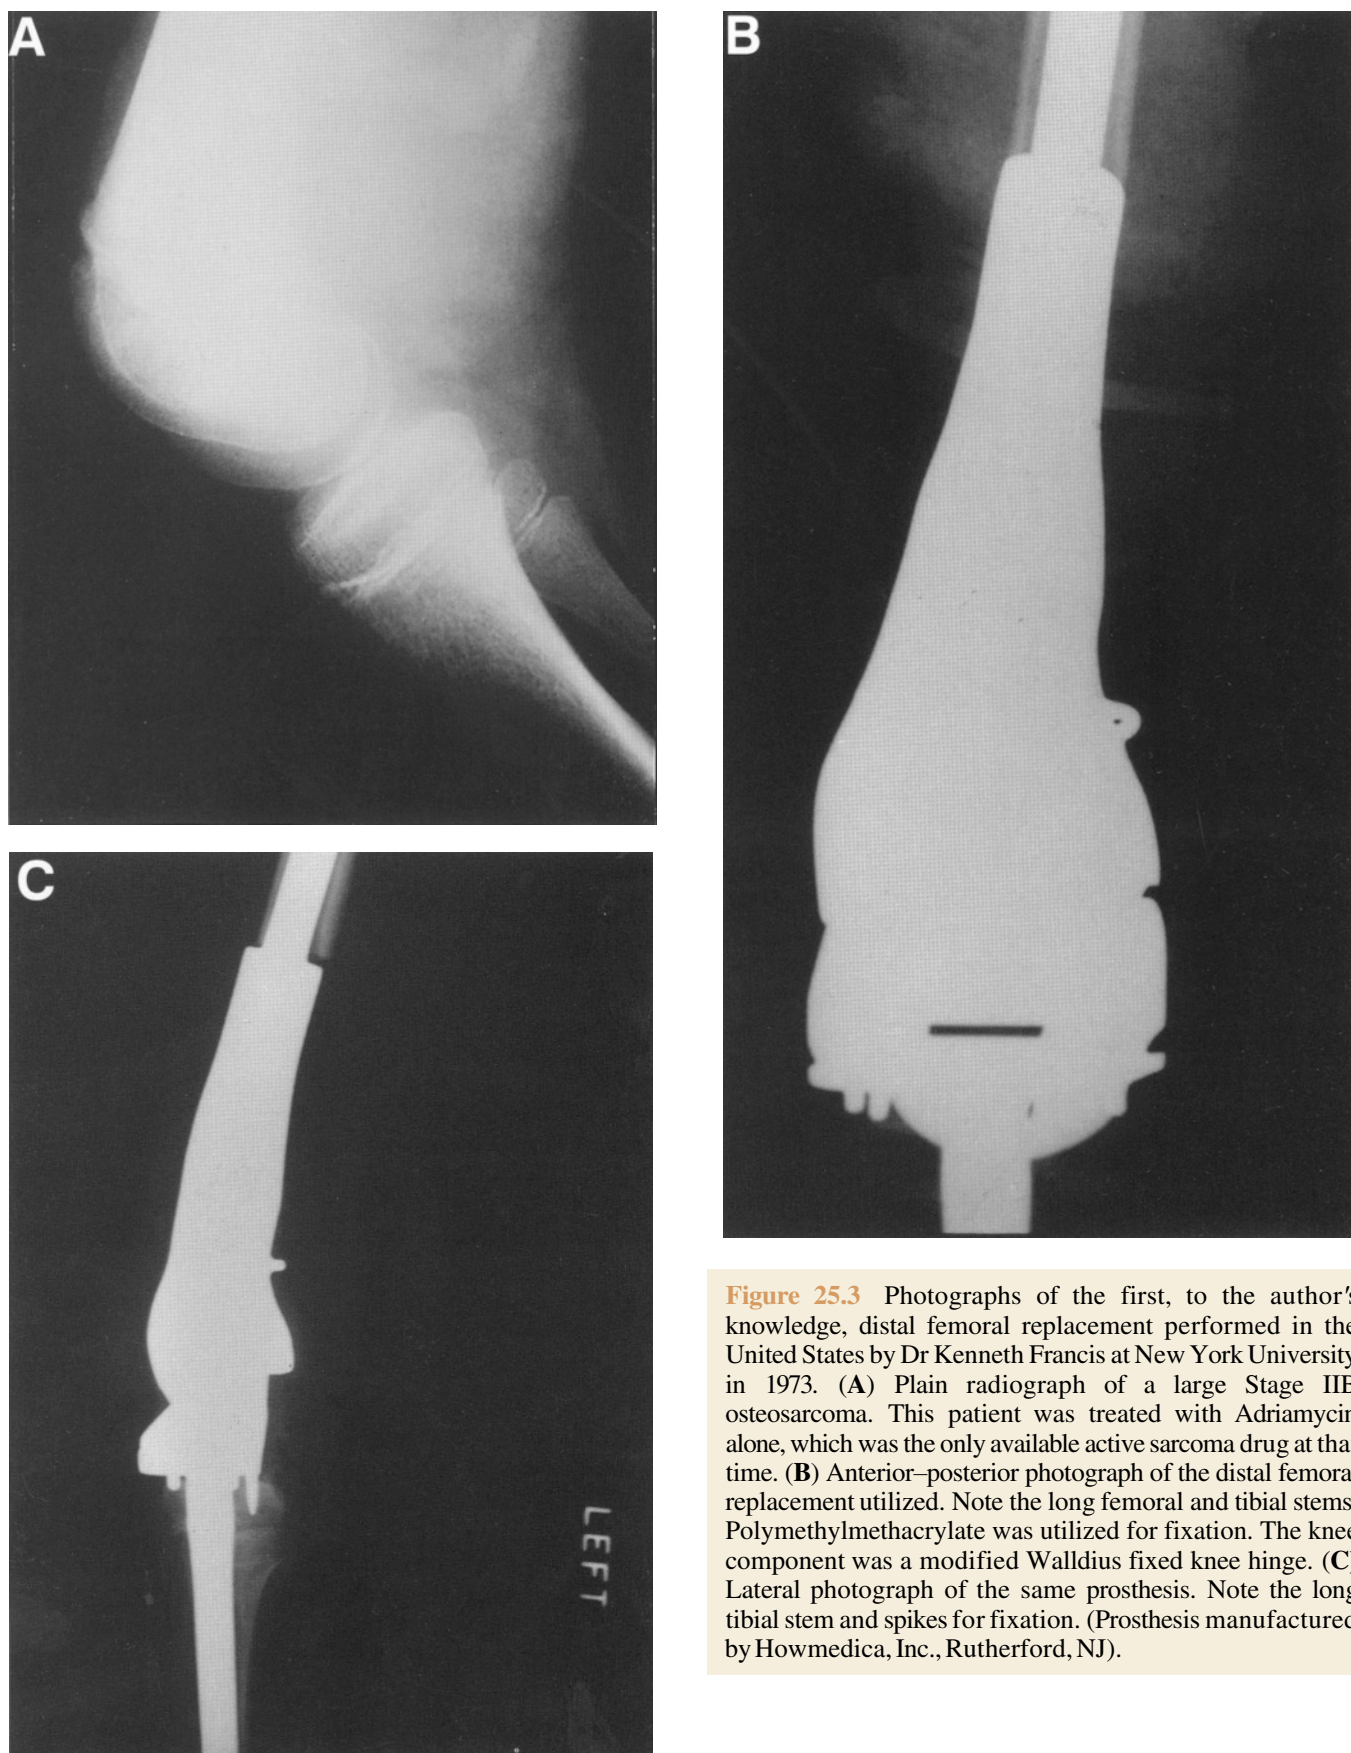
Photographs of the first, to the author's knowledge, distal femoral replacement performed in the United States by Dr Kenneth Francis at New York University in 1973. (A) Plain radiograph of a large Stage IIB osteosarcoma. This patient was treated with Adriamycin alone, which was the only available active sarcoma drug at that time. (B) Anterior–posterior photograph of the distal femoral replacement utilized. Note the long femoral and tibial stems. Polymethylmethacrylate was utilized for fixation. The knee component was a modified Walldius fixed knee hinge. (C) Lateral photograph of the same prosthesis. Note the long tibial stem and spikes for fixation. (Prosthesis manufactured by Howmedica, Inc., Rutherford, NJ).
